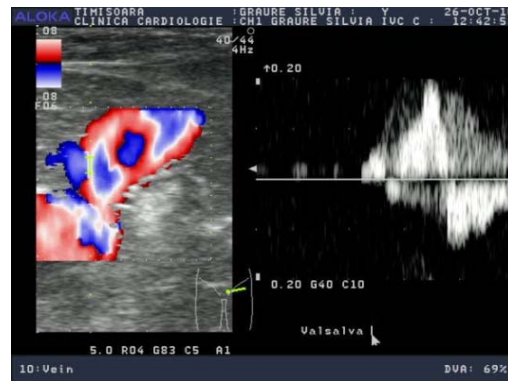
Recurrence of venous disease with significant reflux at ultrasound control 1 year postoperative.
